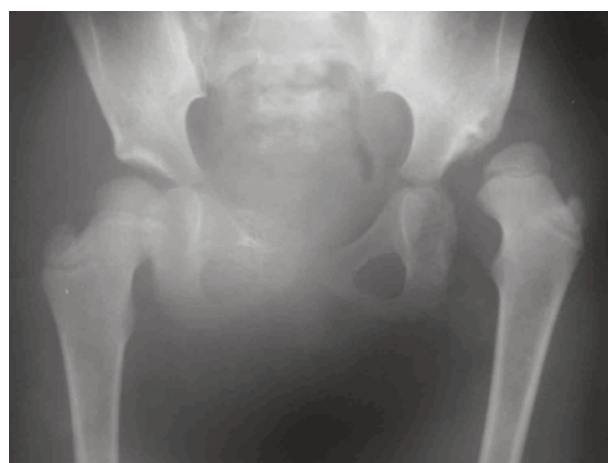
A. Preoperative anteroposterior pelvis X-ray of a 7-year-old patient, B. Successful reduction was achieved after the proximal femoral osteotomy, DEGA. Osteotomy, and extraarticular grafting (Postoperative 2nd year x-ray).
